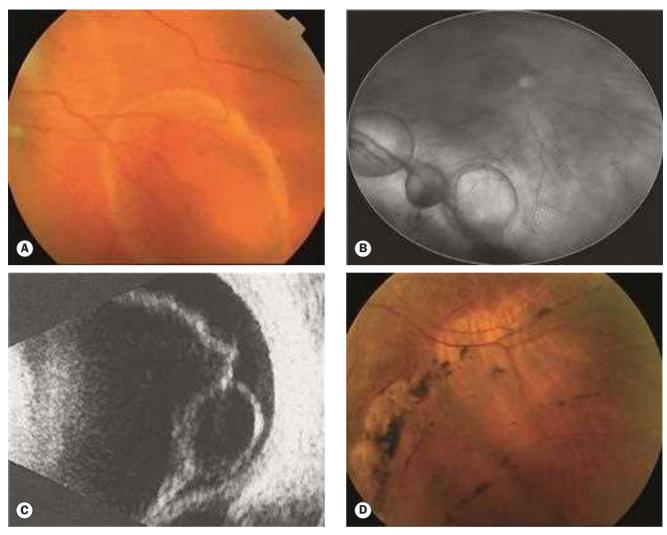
Longstanding retinal detachment. (A) Retinal cysts; (B) multiple cysts in chronic total detachment (red-free wide-field image); (C) B-scan ultrasonogram demonstrating cyst; (D) demarcation line surrounding localized inferior subretinal fluid (Courtesy of C Barry – fig. B; RF Spaide, from Diseases of the Retina and Vitreous, WB Saunders 1999 – fig. C)
